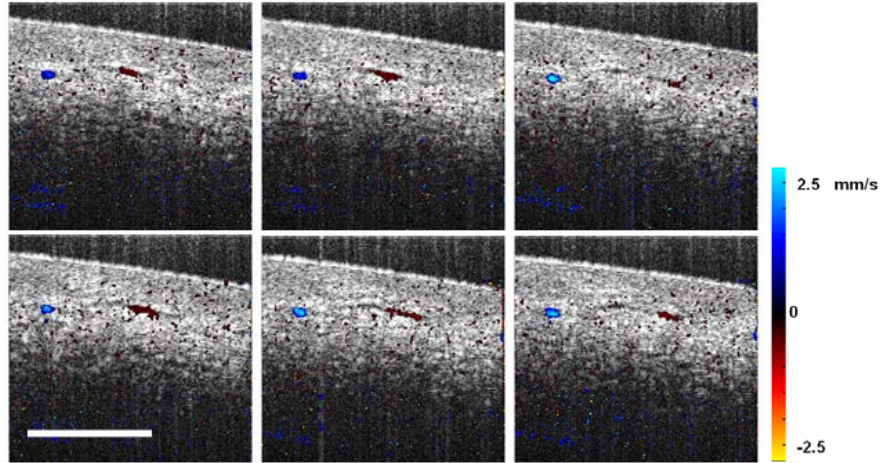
Consecutive Doppler images and Doppler OCT multimedia of the microvessels in the human labial tissue. The color bar represents the velocity of scatterers in the axial direction. Blue and red hues correspond to two opposite blood flow directions. Microvasculature as small as $16\ \mu\text{m}$ is detectable using the SD-OCT system. Scale bar = $500\ \mu\text{m}$. Lateral field of view in the multimedia: $1\ \text{mm}$ by $1\ \text{mm}$ (Media 1)
